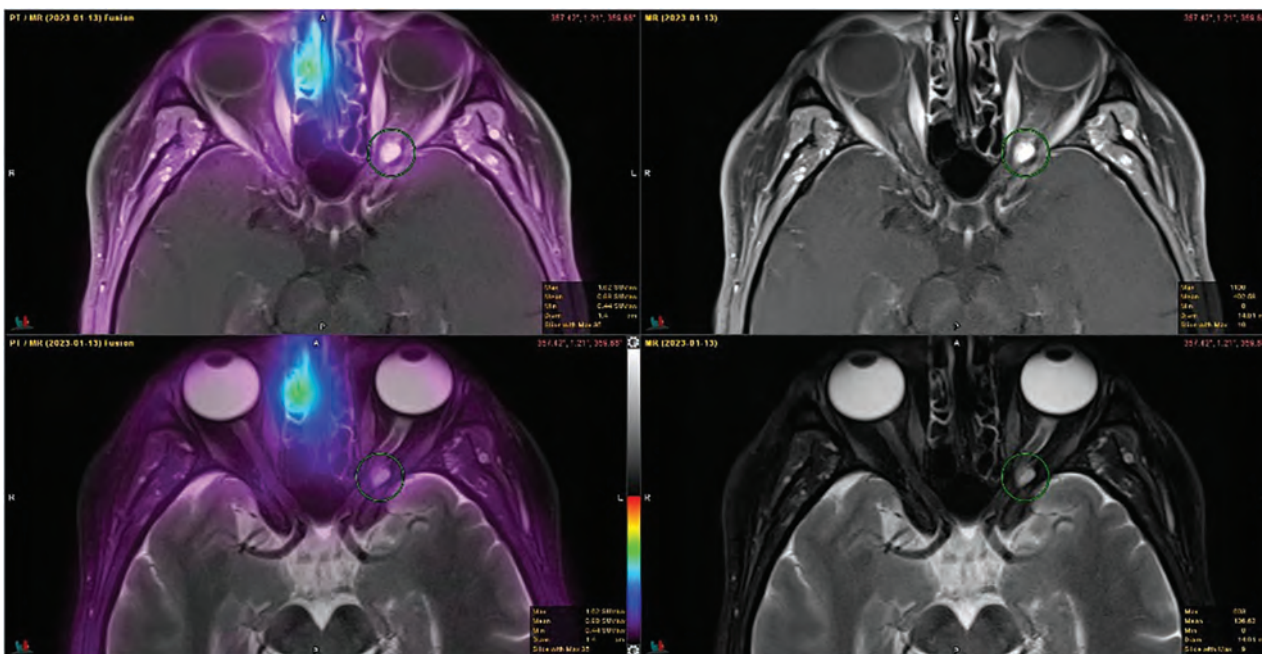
A 52-year-old woman presenting with a visual field disturbance and contrast-enhanced MR imaging demonstrating a left orbital mass concerning for orbital nerve sheath meningioma versus orbital cavernous venous malformation (cavernous hemangioma). Findings of SSTR-PET were negative and represent an orbital cavernous venous malformation. The patient was subsequently referred for surgical management.
